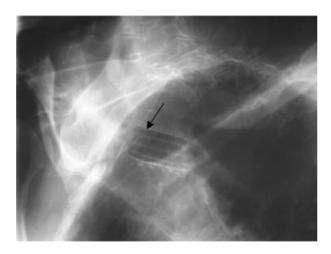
Lateral cervical X-ray of patient 4 showing severe kyphosis and the displaced stent (arrowed).
